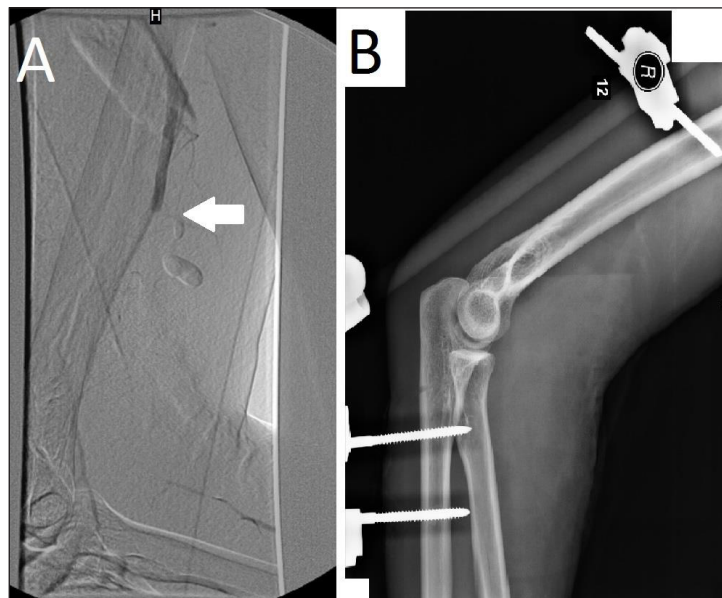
A – the angiogram shows the interruption of the flow in the proximal part of the saphenous vein graft (white arrow) on the first postoperative day. B – the lateral elbow radiograph after application of external fixation device
